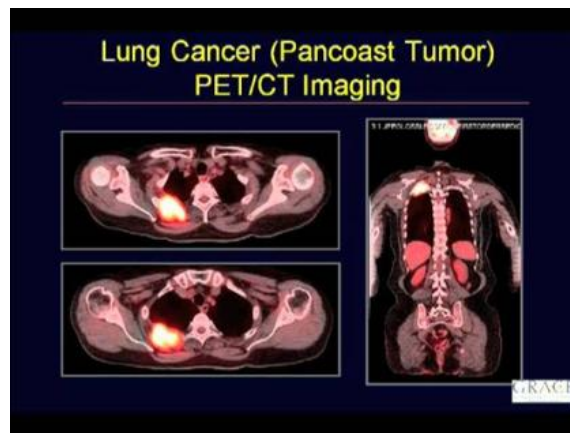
(PET-CT Image Of Lung Cancer)
